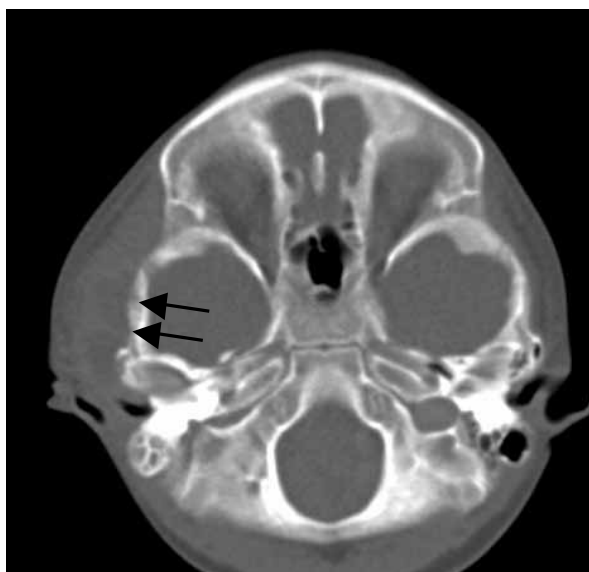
Axial CT scan of temporal bone showing right mastoid abscess and zygomatic root abscess (arrows)
